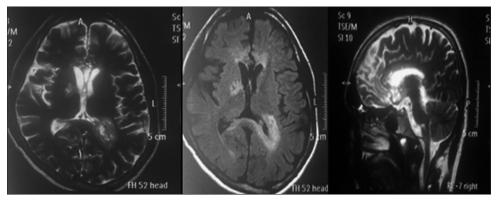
Magnetic resonance imaging brain showing prominent nodular hyperintensities around the left occipital horn, bilateral frontal horns, right thalamic region, and altered signal intensities in the corpus callosum
